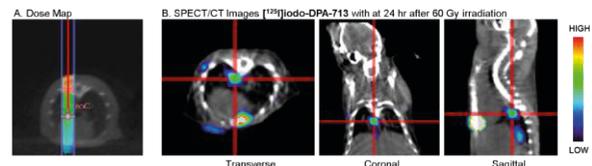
A. Dose map showing the Posterior-Anterior beam with 60Gy dose to the right lung. B. SPECT/CT images with ^{125}I -iodoDPA-713 at 24 hr after 60Gy irradiation to the right lung. The red cross shows the inflammation in the right lung.
